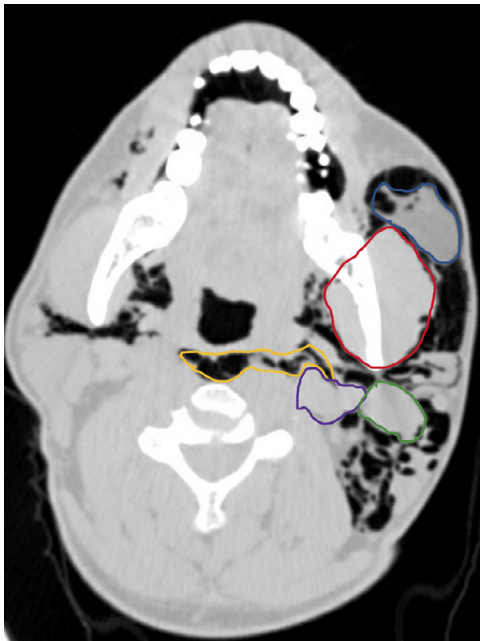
Axial view of a computed tomography (CT) neck scan without contrast in the suprahyoid neck at the level of the mandibular ramus. Extensive air emphysema outlines the buccal space and buccal fat (*blue*), masticator space (*red*), parotid space (*green*), retropharyngeal space (*yellow*), and carotid space (*purple*). There is also air around the masticator space on the contralateral side.
